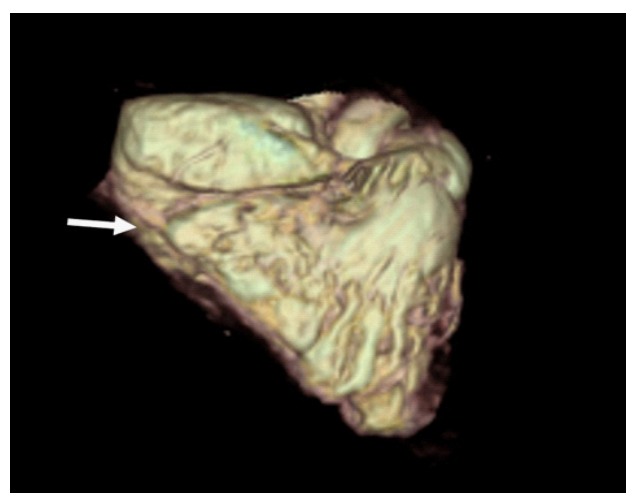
A 3D volume-rendered computed tomographic angiography showing a diverticulum arising from anterior margin of right ventricle (white arrow). RV=Right Ventricle.
